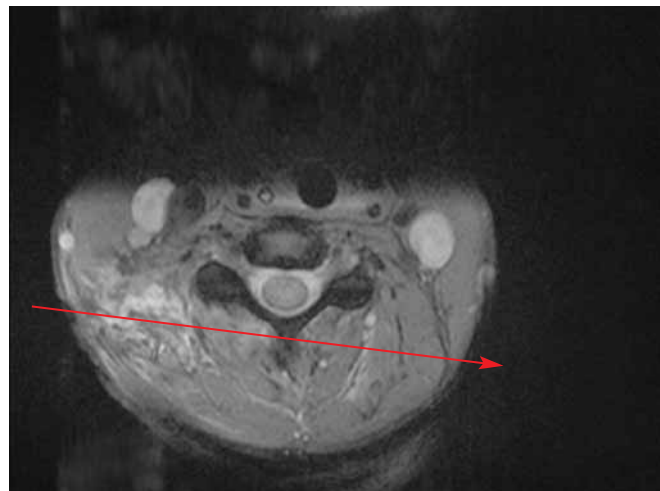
Coronal section of the MRI performed after arrival in UK showing the path of the missile away from the spinal canal and cord.
